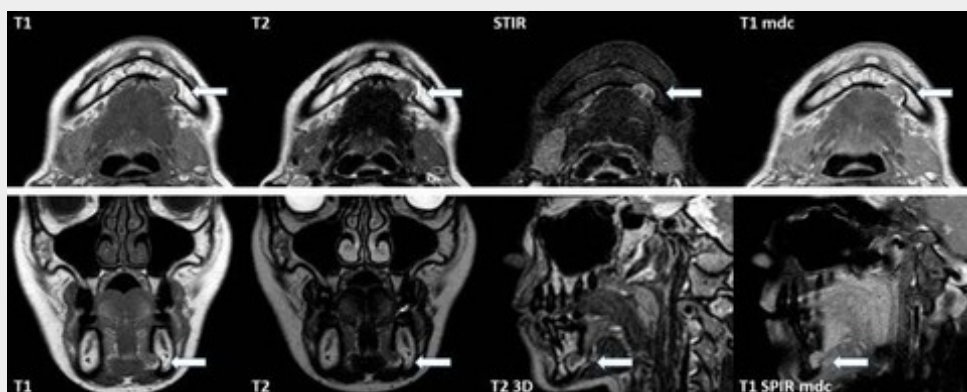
MRI study performed on a 1.5 T unit with the following multiplanar sequences: TSE T1 without and with fat saturation after i.v. administration of a paramagnetic contrast medium, T2 3D, STIR, and FFE T1 3D with fat saturation after i.v. administration of a paramagnetic contrast medium.
